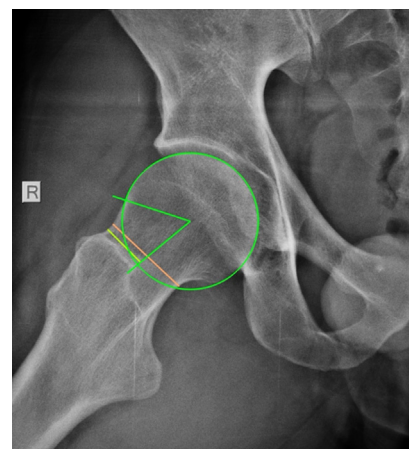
The alpha angle measurement on Dunn View hip X-ray, using the oval and angle instrument in OsiriX software.
